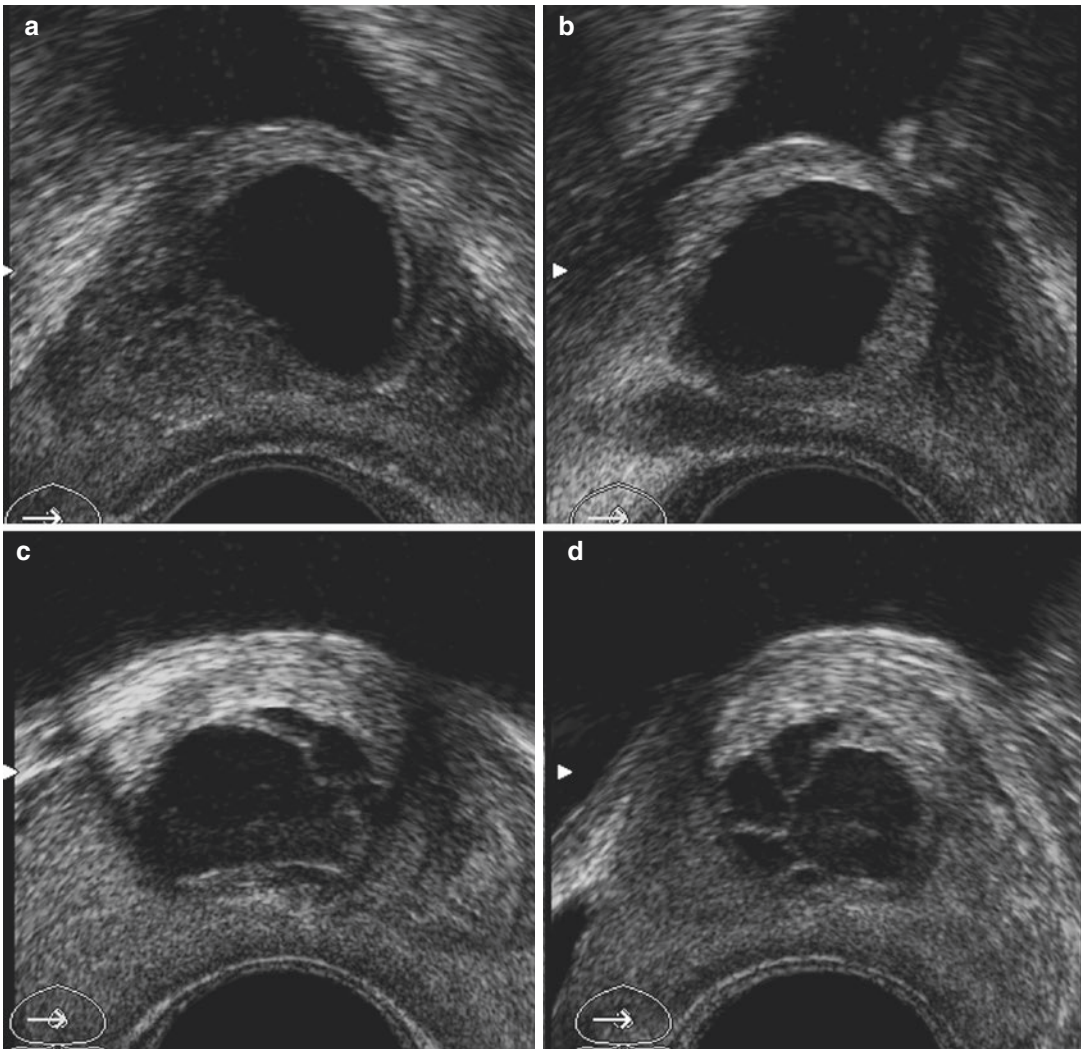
Simple parenchyma cysts located close to the bladder neck and prostatic urethra that cause obstructive urinary symptoms. Ultrasound axial view of simple (a) and loculated (c) cyst; longitudinal view (b) of simple and loculated (d) cyst
